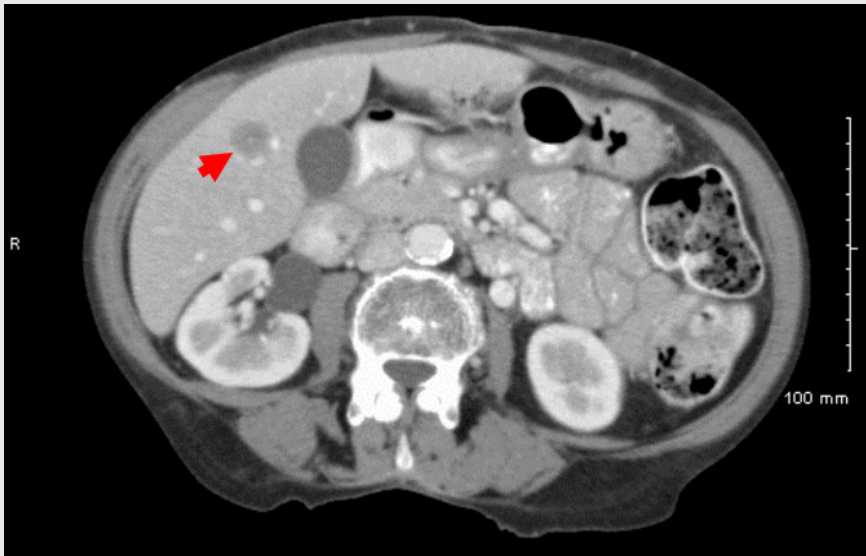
CT visualization of a liver mass (red arrow) in a female patient with a history of lung cancer.
